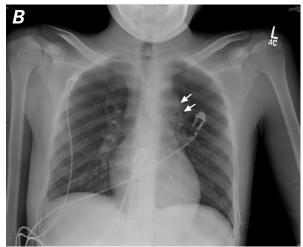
A) Chest radiograph upon initial admission shows a normal cardiac shadow, a clearly delineated aortic arch (arrows), and normal lung fields. B) On hospital day 4, the superior mediastinum (arrows) had widened. The lung fields remained normal.
